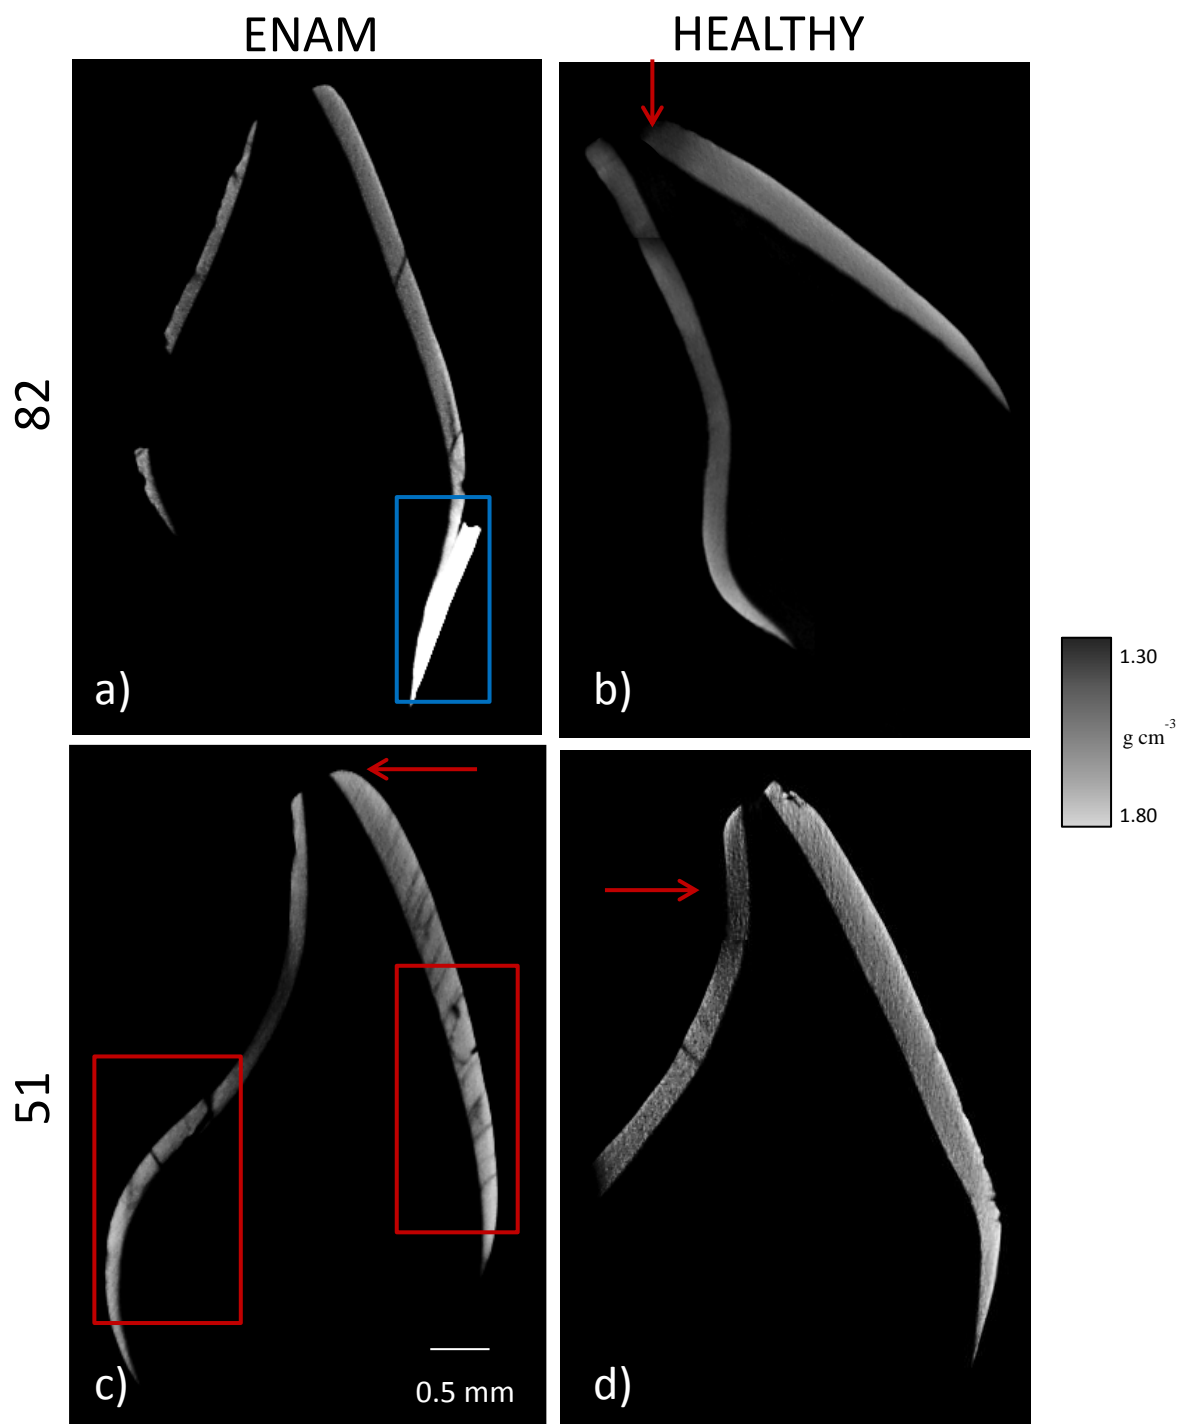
High contrast X-ray microtomography images showing the mineral concentration distribution in samples a) ENAM82, b) HEALTHY82, c) ENAM51 and d) HEALTHY51.
